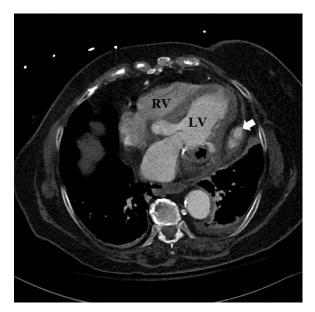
Axial computed tomography angiogram showing the basal location of the LV pseudoaneurysm neck (*white arrow*, LV pseudoaneurysm; *black arrow*, neck of the pseudoaneurysm). LV, left ventricle; RV, right ventricle.
